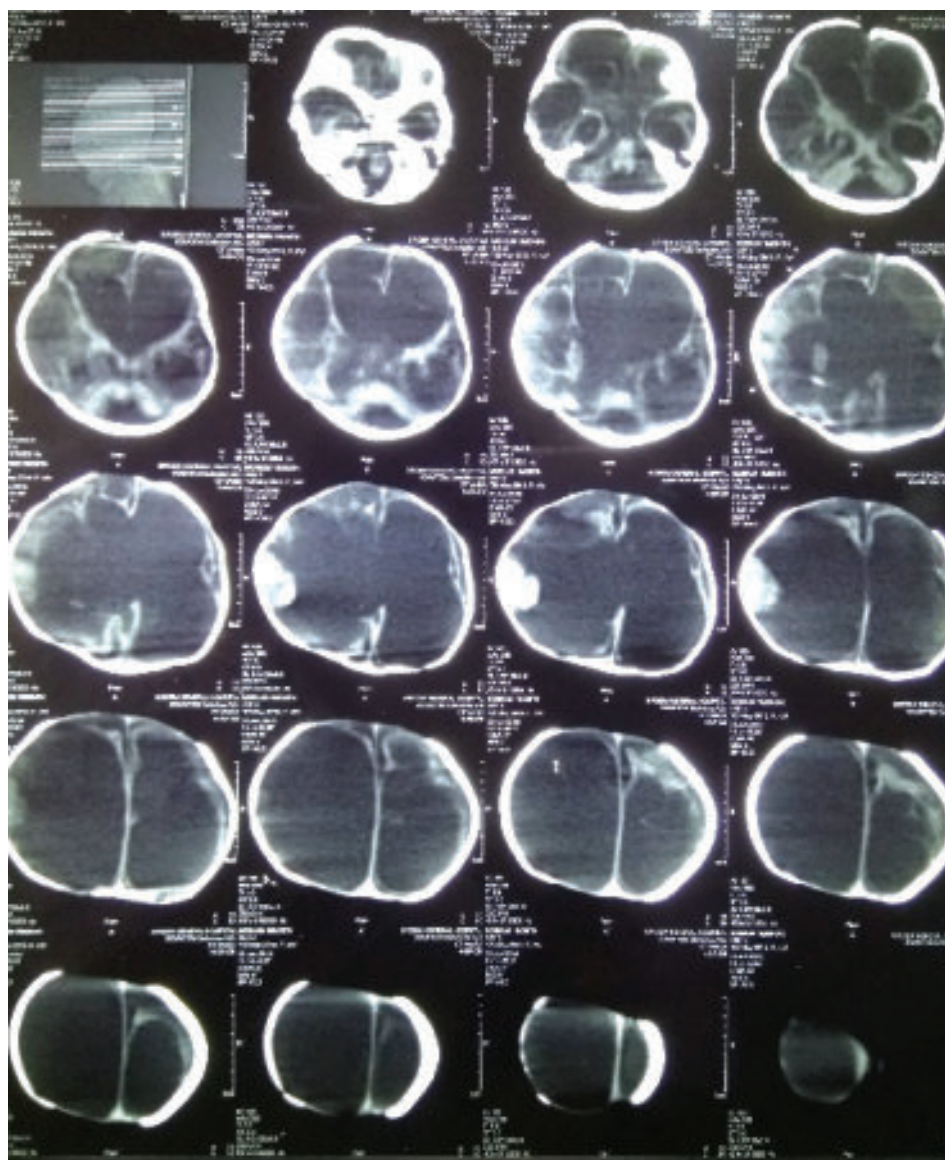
CT scan of head showing dilatation of all ventricles.
